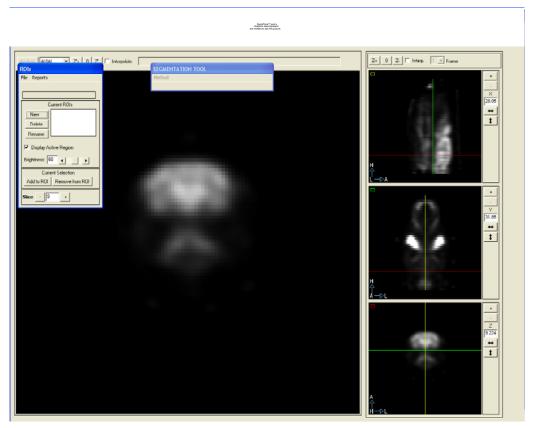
Segmentation floating windows over VISTA-CT Analysis Mode
